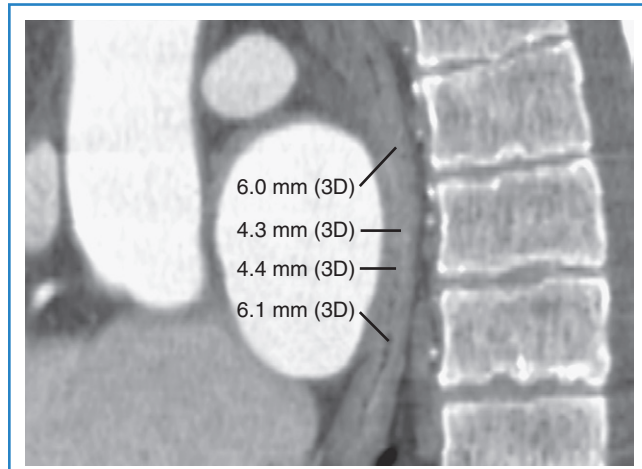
Relationship of the esophagus to the posterior left atrium. Left lateral three-dimensional (3D) computed tomography images of the left atrium are shown. The esophagus is seen as a translucent structure near the left atrial posterior wall over the left pulmonary veins. Measurements at four different locations between the left atrium and the esophagus are shown.
